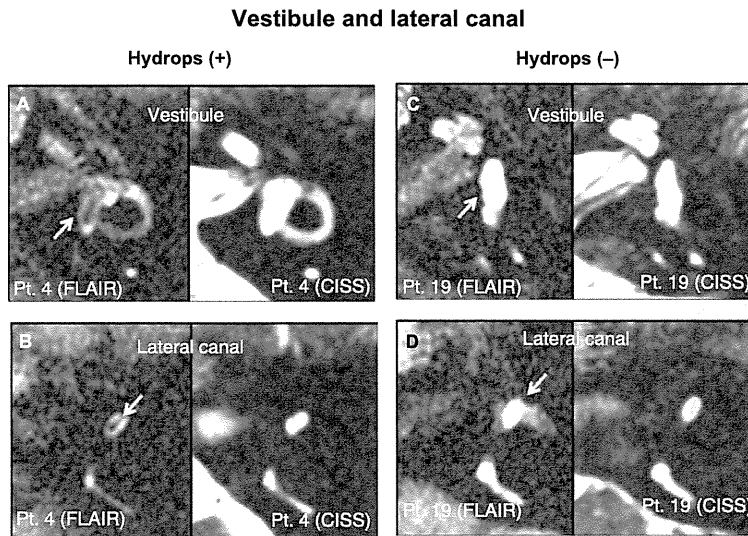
Hydrops-positive (A and B) and hydrops-negative (C and D) vestibule and lateral canal in 2D-FLAIR and CISS images. (A and B) In 2D-FLAIR images, enlarged vestibular (A) and lateral canal (B) endolymphatic space was seen as low or no signal intensity area (arrows) surrounded by a gadolinium-enhanced high signal intensity perilymphatic space. (C and D) In 2D-FLAIR images, no remarkable low signal intensity area was found in the vestibule (C) and lateral canal (D). CISS images in the same plane were helpful in identifying inner ear structures. Numbers in the figures indicate patient ID numbers.
